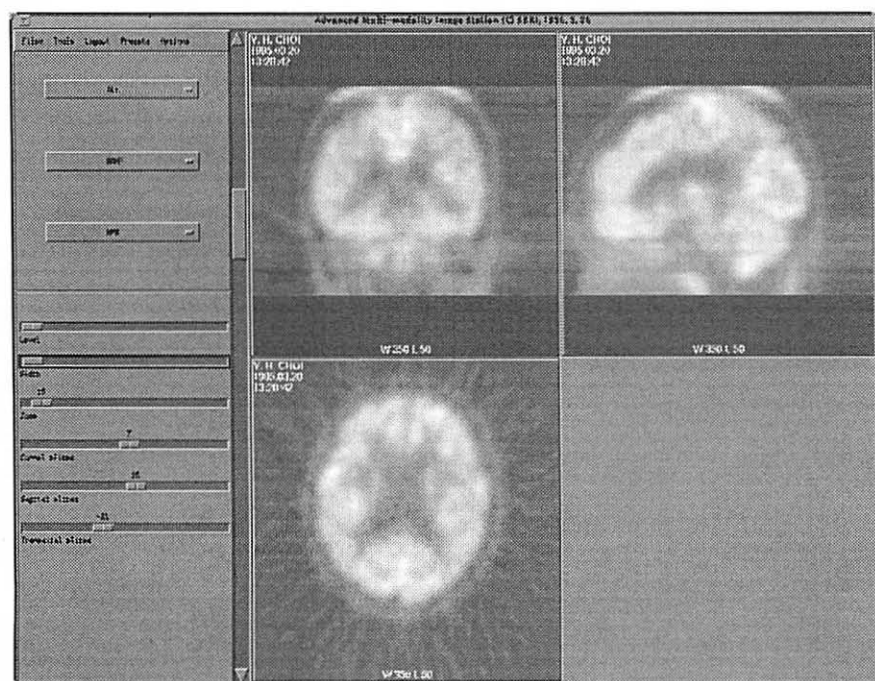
The 35 [^{18}F]FDG PET images are visualized interactively in the multi-planar reformat viewer.
